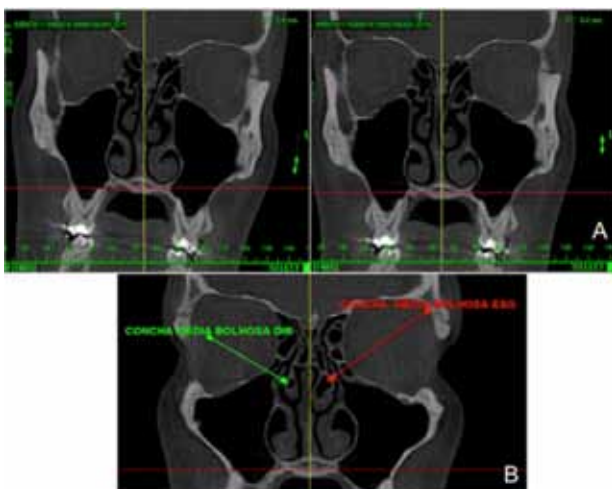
CBCT coronal slice showing: (a) previous alignment of the image to the occlusal plane (in red); (b) bilateral middle concha bullosa.
